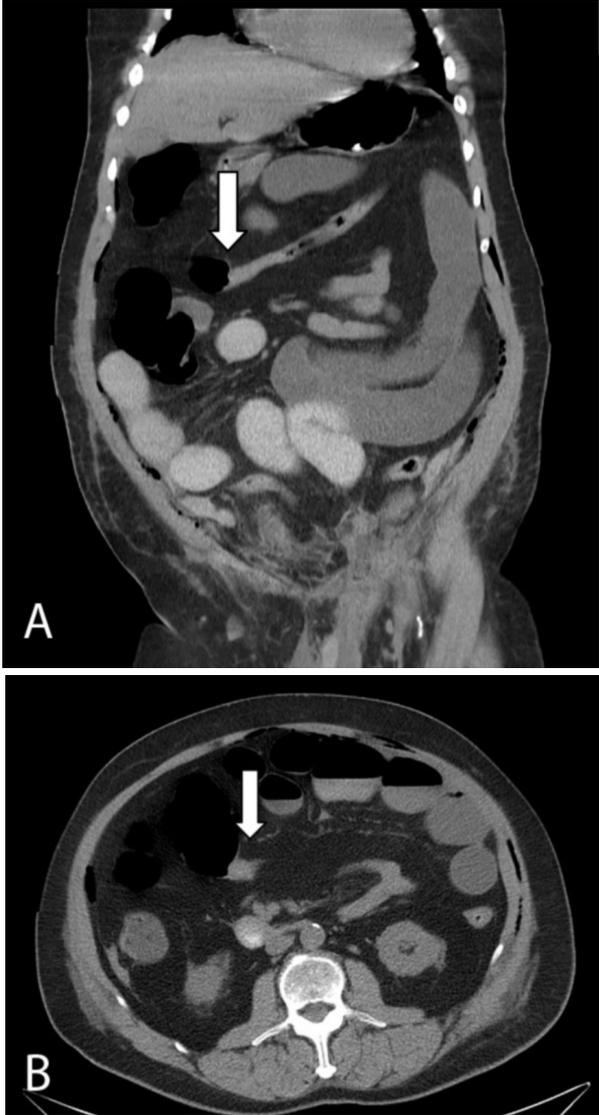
Coronal (A) and axial (B) CT scans of the abdomen show dilated small and large bowel with a transition point (white arrows) in the midtransverse colon, consistent with a high-grade obstruction.
